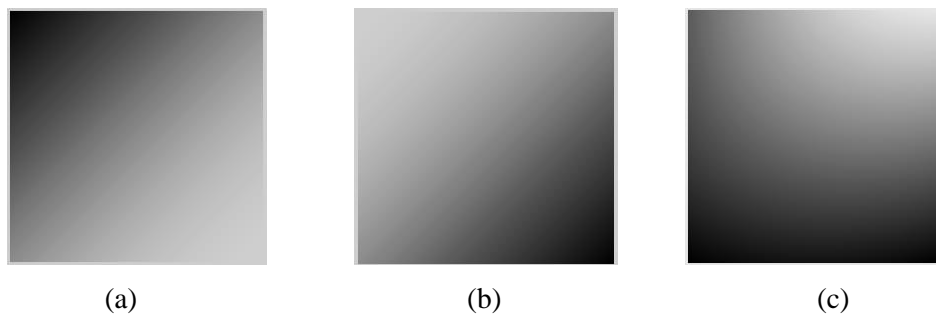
Example of IIIH used in synthetic MRI data set (a) sin (b) cos (c) sincos function
